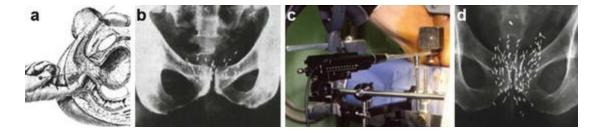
Brachy therapies evolve. (a) The first prostate brachytherapies involved digital rectalguidance. (b) X-ray following one of these DRE-guided brachytherapies. (c) US-guided transperineal brachytherapy. (d) X-ray following this method (many more seeds dispersed regularly)
